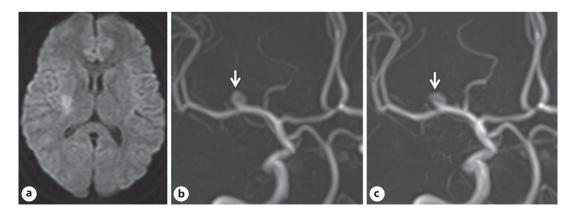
Initial magnetic resonance imaging (a) and magnetic resonance angiography (MRA) revealed acute infarction of the right basal ganglia and an aneurysm of the right middle cerebral artery (b arrow). MRA on day 4 revealed the change in the shape of the aneurysm (c).
